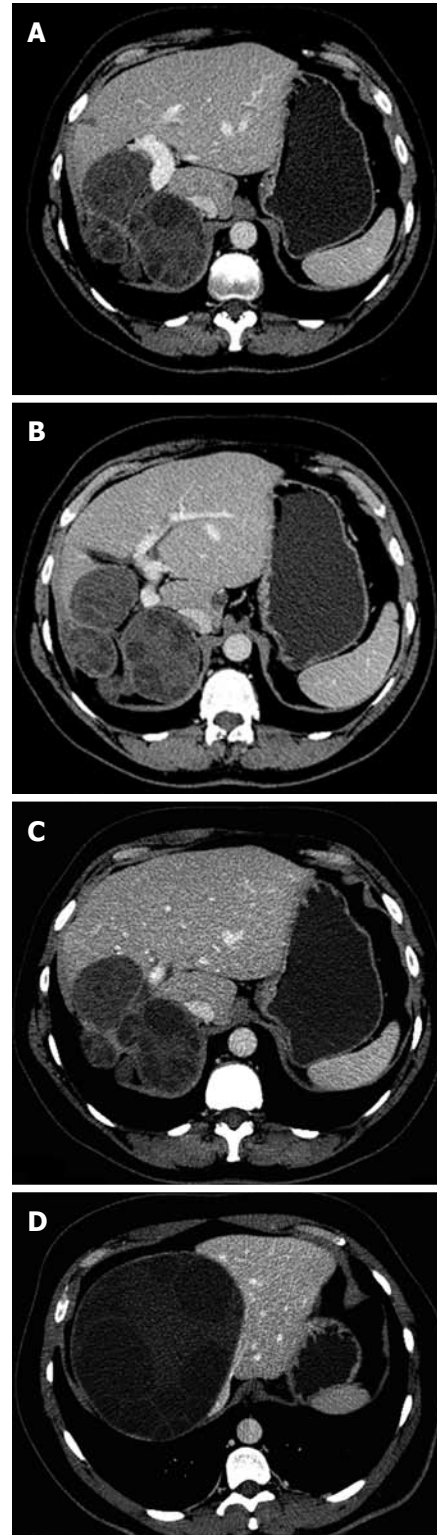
Computed tomography scan (A, B, C, D) shows some unenhanced hypoattenuating masses with well defined borders occupying the right lobe of the liver; multiple round daughter cysts are seen peripherally inside the lesion (type II). Note the "rosette appearance".
